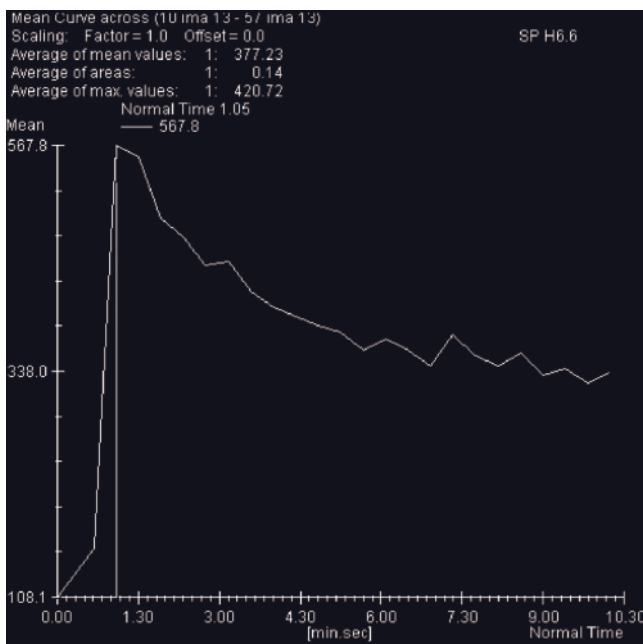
(Continued) T2-weighted echo-train spin-echo coronal (k) and transverse (l) images in a sixth patient demonstrate involvement of the medial portions of bilateral seminal vesicles. Imaging in two planes provides increased observer confidence of diagnosing tumor involvement. Prostate carcinoma, diffuse involvement with extracapsular extension, seminal vesicle and bladder invasion, Stage T4. Transverse (m, n) and sagittal (o) high-resolution T2-weighted fast spin-echo images at 3.0T demonstrate diffuse low-signal-intensity tumor involving the peripheral and transitional zones of the prostate. The contour bulging and extracapsular spiculations suggest the extracapsular extension bilaterally and posterolaterally. There is also neurovascular bundle invasion (arrows, m, p). The tumor invades the bladder wall and trigone and causes obstruction of bilateral ureters (arrows, n, o). The seminal vesicles (open arrow, o) are seen as hypointense structures because of the tumor invasion. The tumor shows
